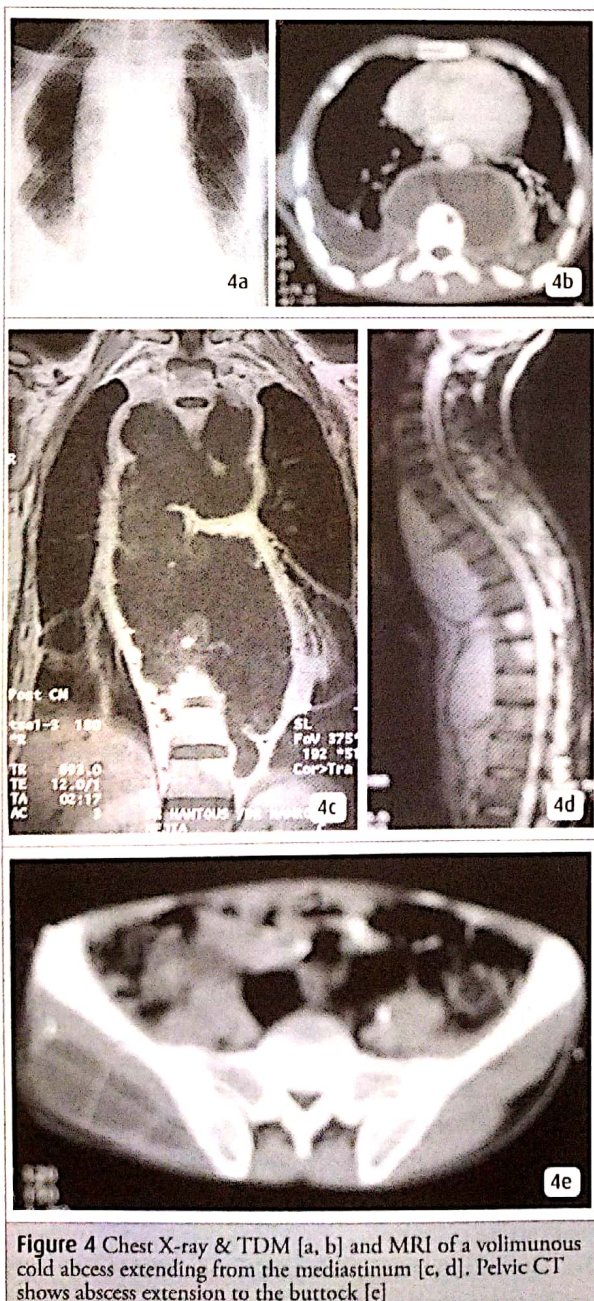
Chest X-ray & TDM [a, b] and MRI of a voluminous cold abscess extending from the mediastinum [c, d]. Pelvic CT shows abscess extension to the buttock [e]
